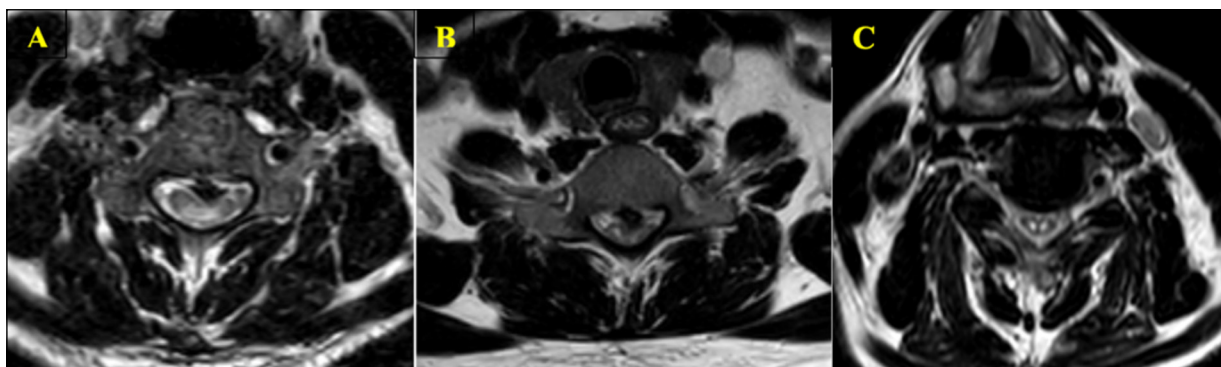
Axial T2-weighted magnetic resonance imaging. A, Type 1, showing a diffuse pattern of intramedullary hyperintensity on T2-weighted imaging, occupying more than two-thirds of the axial dimension of the spinal cord with an obscure and faint border. B, Type 2, showing focal patterns of intramedullary hyperintensity on T2-weighted imaging, occupying less than two-thirds of the axial dimension of the spinal cord with an obscure and faint border. C, Type 3, showing focal patterns of intramedullary hyperintensity on T2-weighted imaging occupying less than two-thirds of the axial dimension of the spinal cord with a well-defined and distinct margin.
